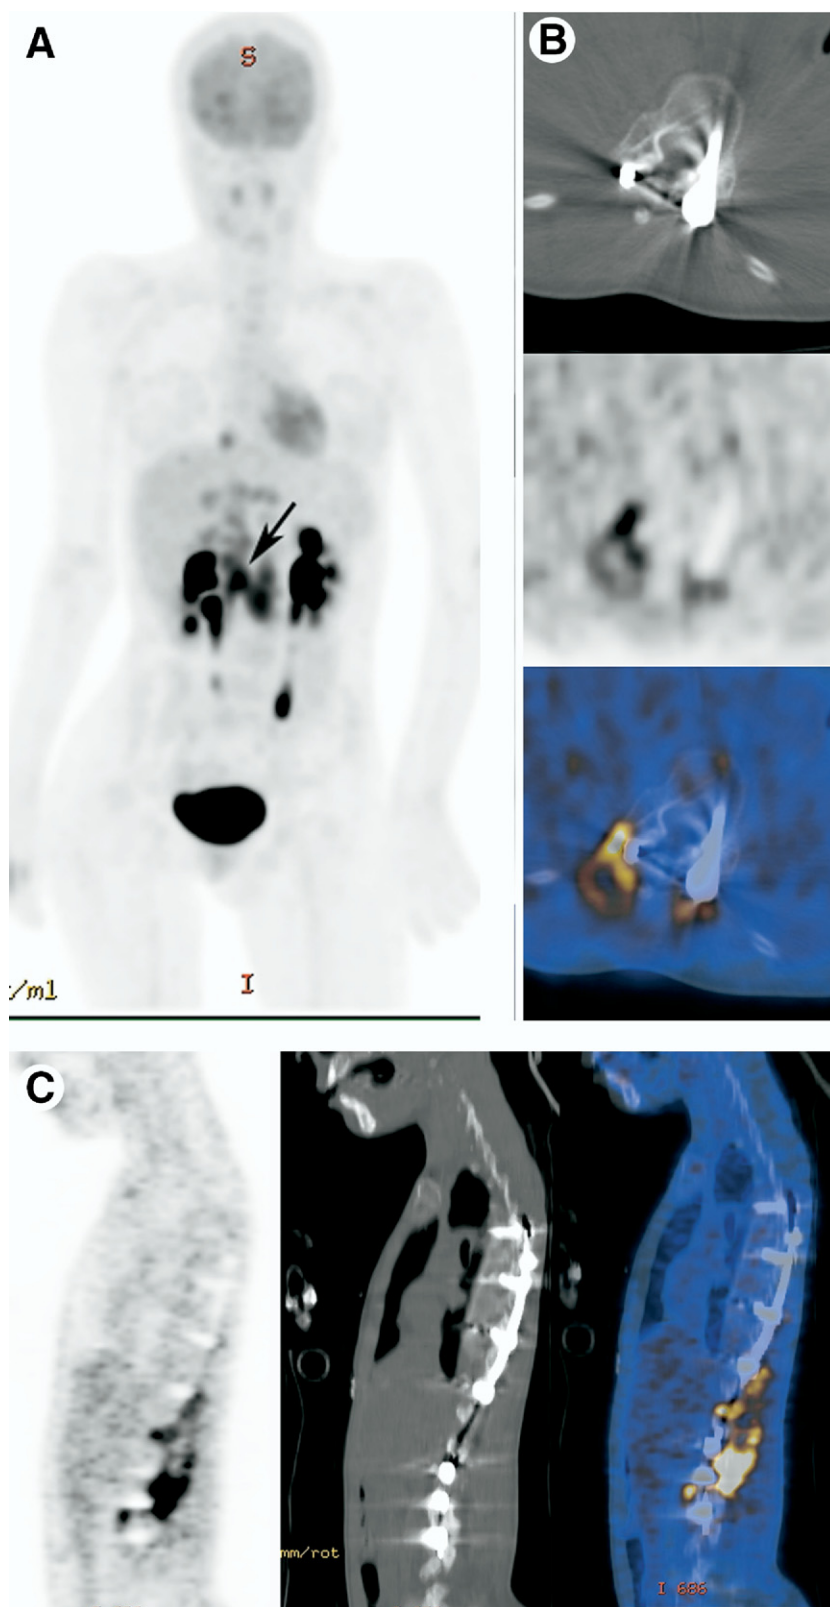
A 19-year-old woman with pain and increased inflammatory blood parameters 18 months after lumbar spine stabilization surgery because of severe scoliosis. (A) MIP shows increased FDG accumulation in the lower thoracic and upper lumbar spine (black arrow). Axial (B) and sagittal (C) FDG-PET/CT show increased FDG uptake around the screws and the adjacent muscles of the spine. Infection of the soft tissues and metallic device was confirmed intraoperatively and the metallic device was removed.
